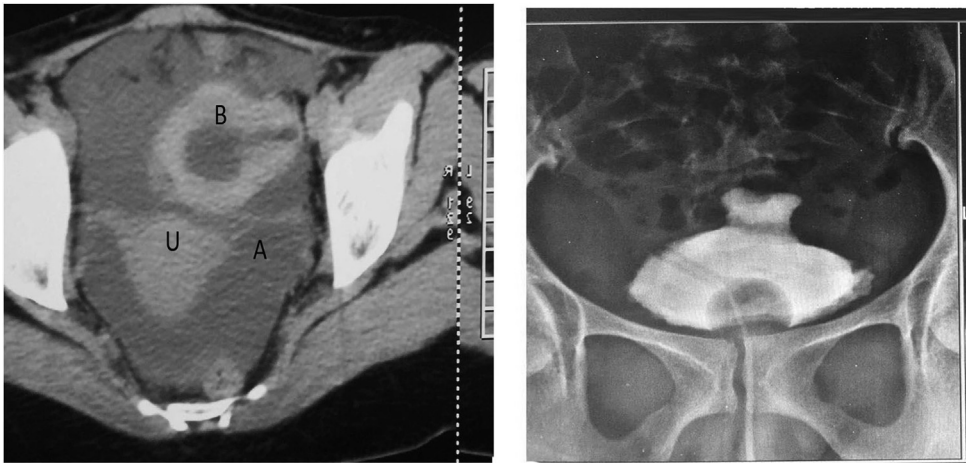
Radiological investigations showing predominantly pelvic ascites on CT and diverticulum with concavity on Cystogram.
